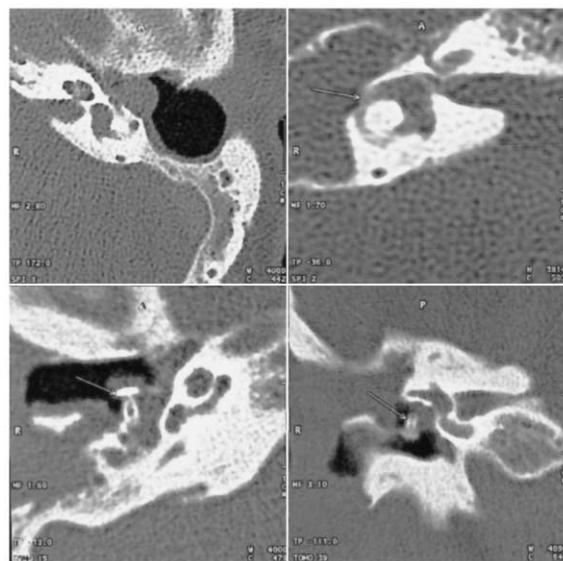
Three patients after mastoidectomy because of cholesteatoma. Upper line left: axial CT shows a convex opacity at the medial tympanic wall, that might be a recurrent cholesteatoma, cholesterol granuloma or inflammatory polyp. Intraoperatively, it was a cholesteatoma. Upper line right: the diagnosis of cholesteatoma was clinically evident. The patient suffered from acute vertigo. Axial CT shows a total opacity and erosion of lateral semicircular canal (arrow). Intraoperatively, a huge cholesteatoma and granulations were found. Lower lines: axial and coronal CT show a dislocation of PORP (arrow) due to recurrent inflammation.
